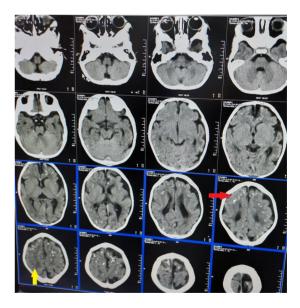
EBV- Axial CT images in a case of perinatal EBV encephalitis shows multiple calcifications at grey white matter junction (red arrow) with white matter hypodensity (yellow arrow). There was associated microcephaly.
